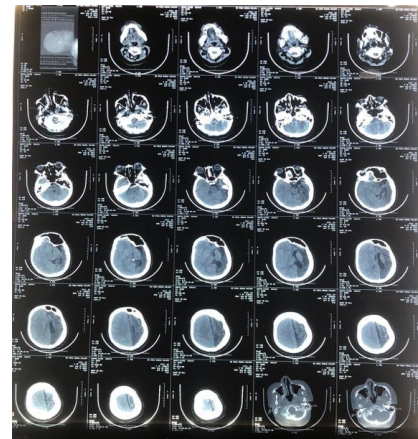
Non-contrast head CT showing left cerebral hemispheric atrophy with enlargement of the left frontal sinus and left-sided calvarial thickening, accompanied by dilatation of the left lateral ventricle. No midline shift.
